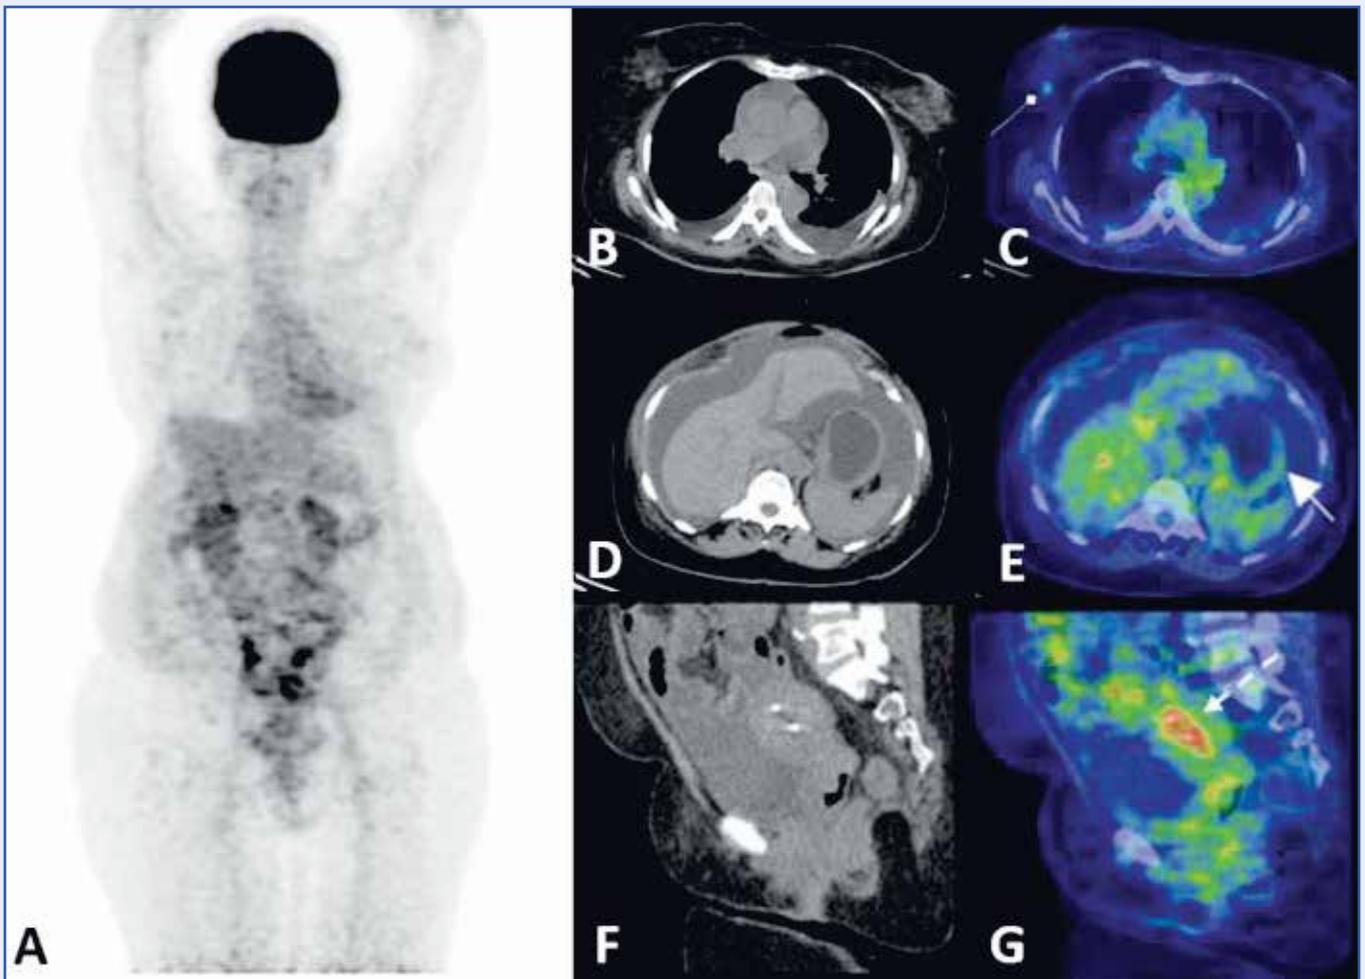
A 71-year-old lady presented with complaints of fatigue, loss of weight and pain abdomen. Blood investigations revealed elevated CA 125 (128.0 units/mL) and CA 19-9 (170.00 units/mL) levels. Ascitic fluid was positive for malignant cells. F-18 FDG PET-CT was performed to evaluate malignancy of unknown origin. Maximum intensity projection image of the staging PET-CT study (A), axial CT (B and D), fused axial PET CT (C and E), show metabolically active lesion in the right breast (arrow with diamond head), pleural effusion, pericardial effusion, stomach wall thickening (solid arrow), metabolically active thickening in the uterine endometrium-cervix (F and G, dotted arrow), ascites, peritoneal deposits and skeletal lesions. These findings posed a diagnostic dilemma as all the rare sites of metastases from ILC was seen in a single case at presentation.
